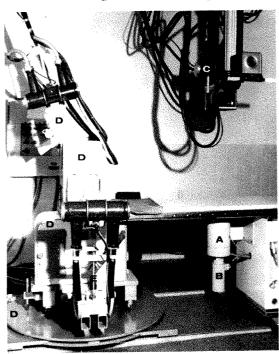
Apparatus arranged for fluoroscopy of femoral region. A. Image amplifier on bracket attached to tablebase. B. Plumbicon T.V. tube. C. Ceiling mounted x-ray tube located directly above center of amplifier. D. Assembly of tube arms and film changers (shown in position for left cerebral angiography). E. Screw for occasional displacement of lateral x-ray beam above or below center of lateral film.
